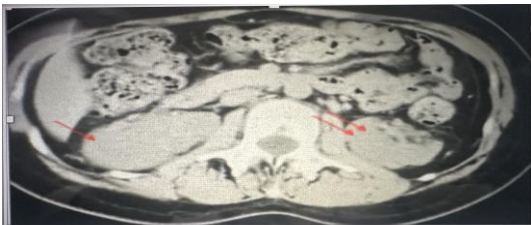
Computerized tomography (CT) of the abdomen showing bilateral malrotated kidneys. Single arrow shows the right malrotated kidney. Double arrows show the reversely rotated left kidney.
